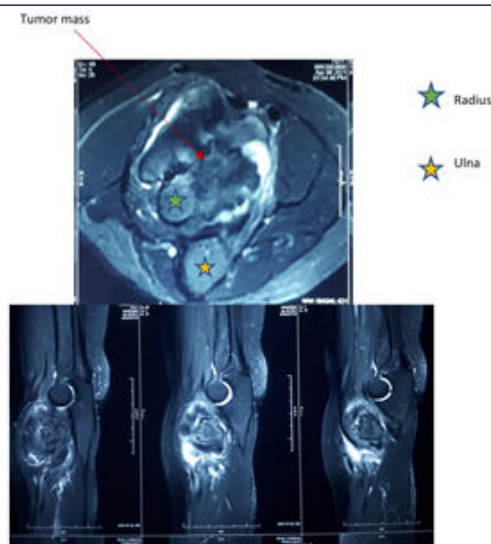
Axial And Sagittal Section Of MRI Showing Heterogeneous Intensity Mass At Level Of Proximal Radio-ulnar Joint.
